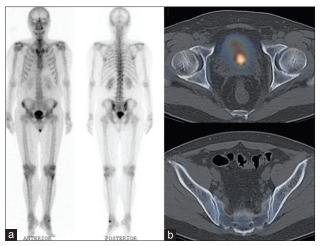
(a) Coronal Tc99m-MDP anterior and posterior wholebody views show essentially symmetrical and homogeneous tracer uptake. No focal osteoblastic lesions were detected. (b) Axial fused SPECT/CT sections of the pelvis show no abnormal tracer focus or CT bone changes for corresponding lesions seen on the MRI pelvis depicted in Figure 1
